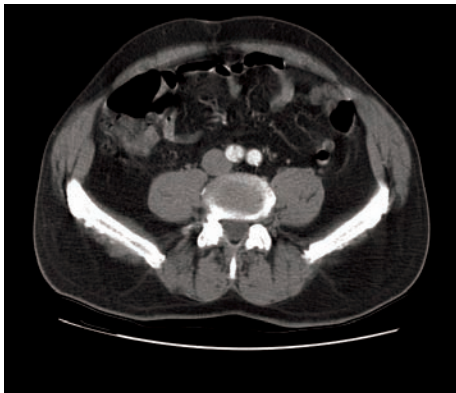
CT scan of Wilard's abdomen, showing the dissection flap extending into the right iliac artery.
